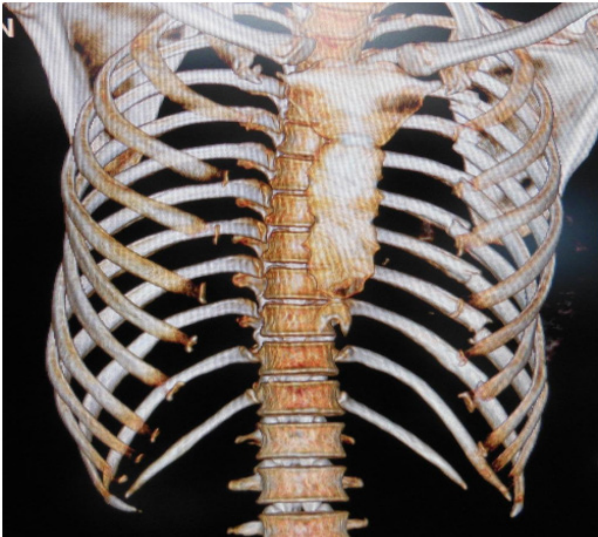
3-D computed tomography demonstrating the displaced fractures.
